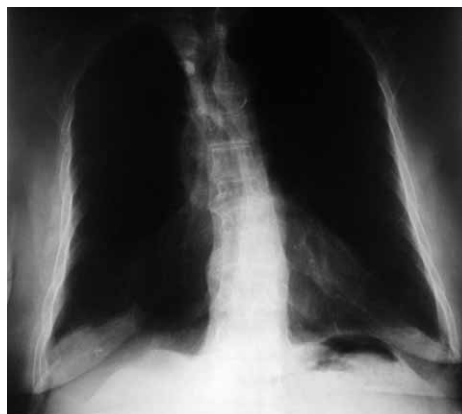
Control X-ray picture after surgery.
